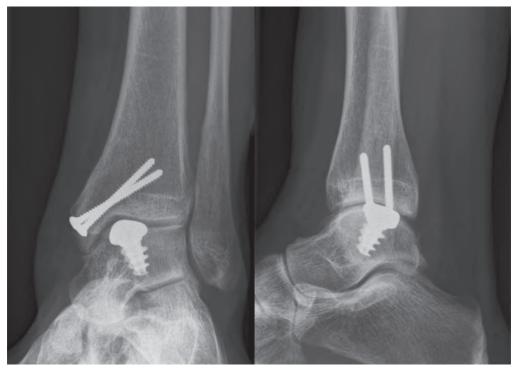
Mortise view and lateral weight-bearing radiographs of a left ankle 3 years postoperatively. Sufficient recession of the implant was confirmed intraoperatively.
